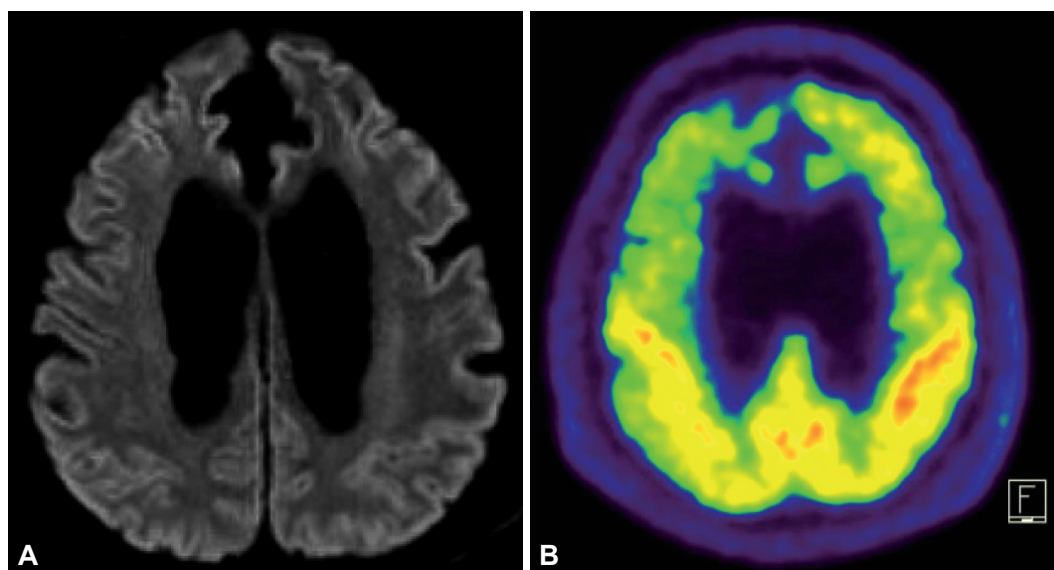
DWI (A) and 18F-fluorodeoxyglucose PET CT (B) obtained 26 months later. Compared with previous DWI and PET CT, there are no interval change. DWI: diffusion weighted image, PET: positron emission tomography.
